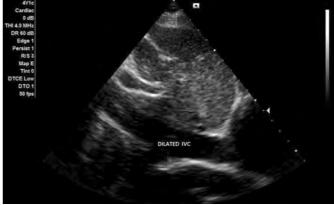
Portable Echocardiography: Dilated Inferior Venecava
